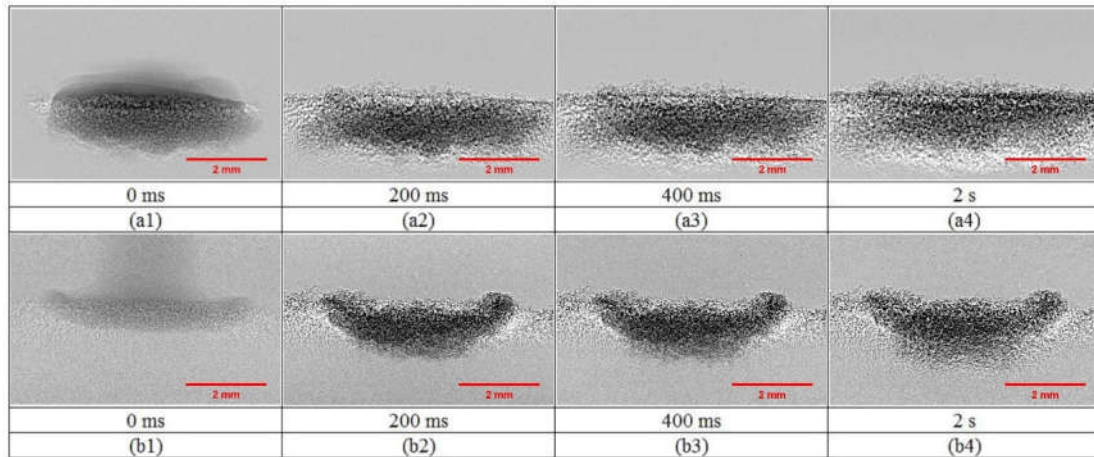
The time sequence X-ray images of the dynamic wetting and nucleation process of MCC powder with a water droplet volume of $15 \mu\text{l}$ and release heights of (a1-a4) 2.5 cm and (b1-b4) 15 cm.
